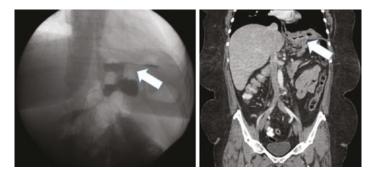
Barium swallow and CT scan (coronal view) demonstrating the presence of a gastro-pleural fistula 2 years post-sleeve gastrectomy
